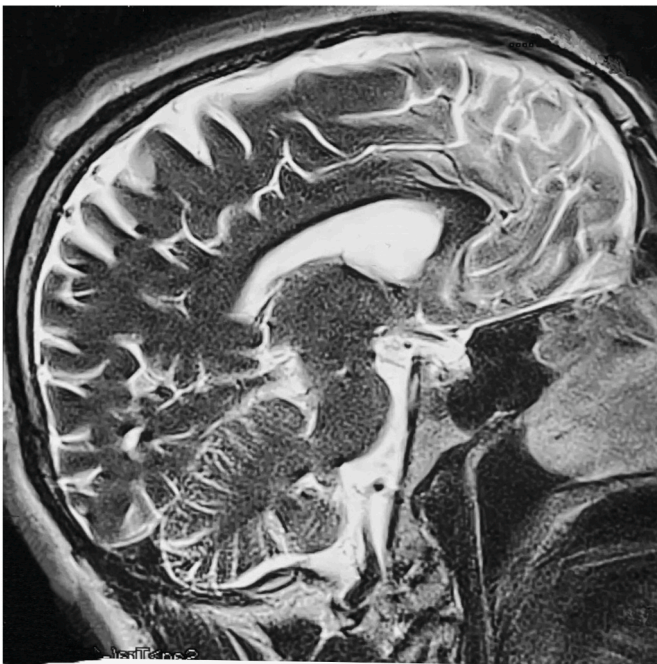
Brain MRI, sagittal section.
